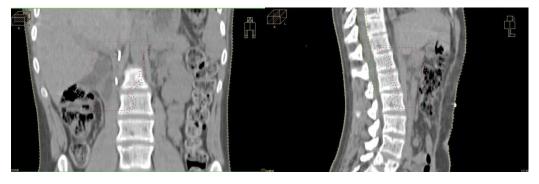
Post-surgery CT Abdomen Sagittal and Coronal views
